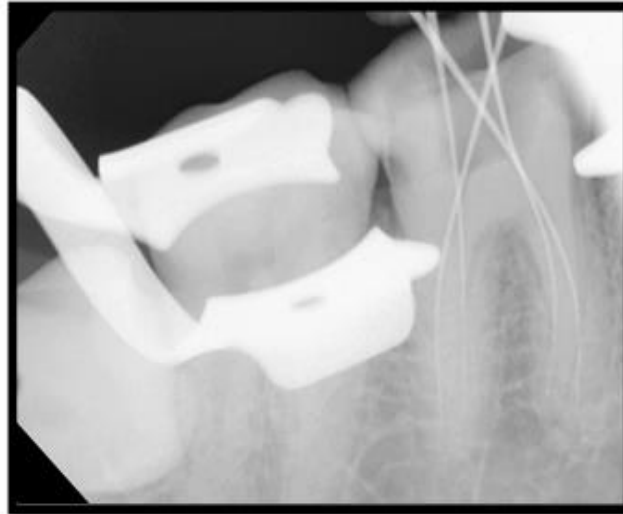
Working length radiograph of #46
